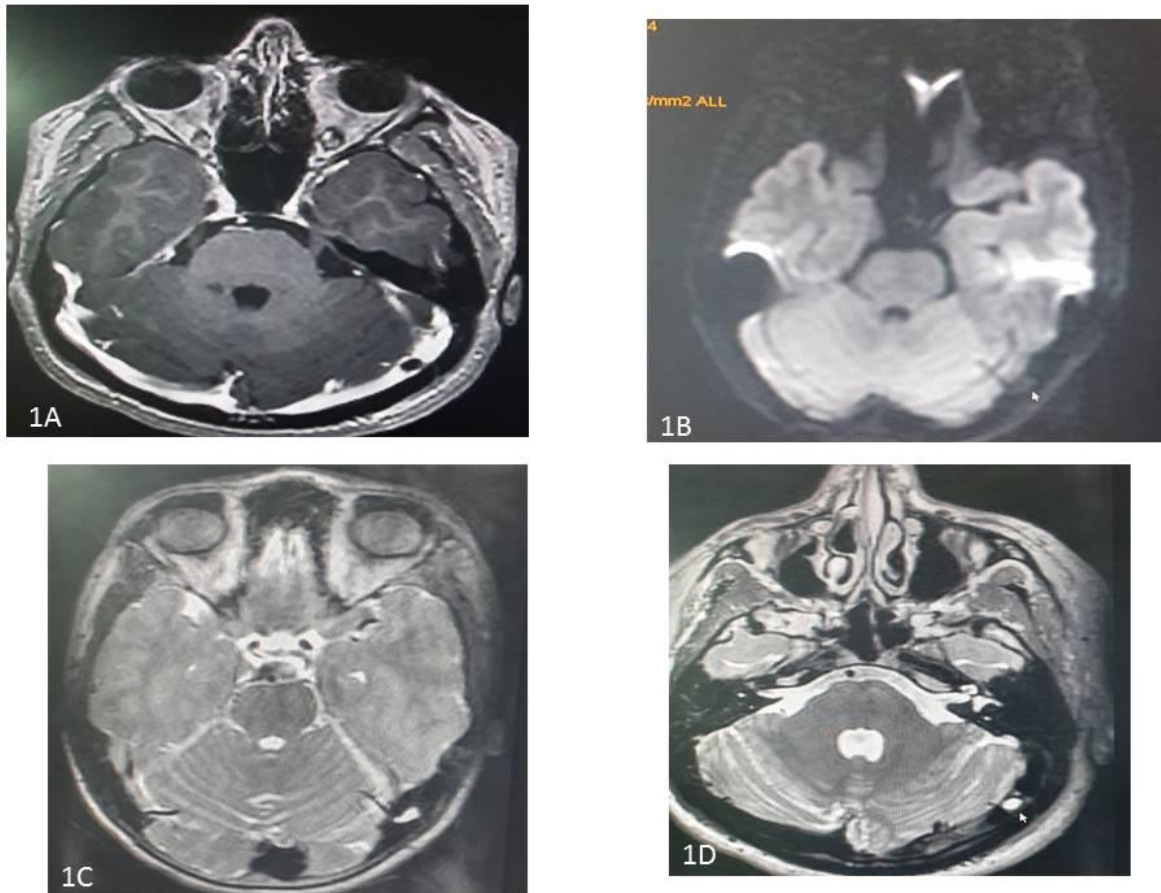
(A) Axial reconstruction of post contrast fat suppressed T1 image shows intraluminal filling defect in left Transverse Sinus. (B) DWI image shows no significant restriction. (C&D) Axial T2 images confirm location, with normal adjacent brain parenchyma.
